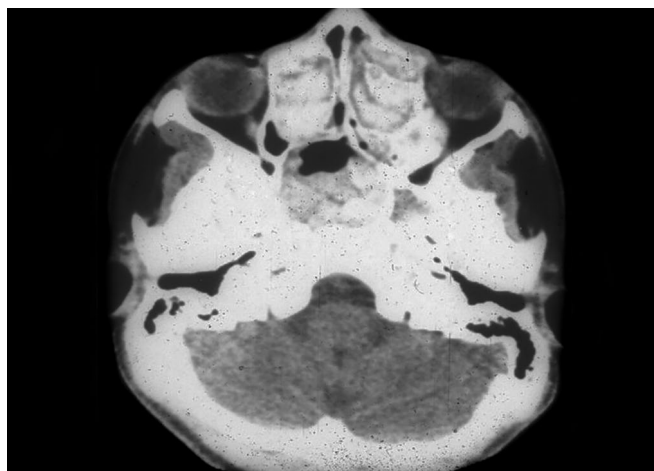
Preoperative CT scan of patient with allergic fungal sinusitis.
